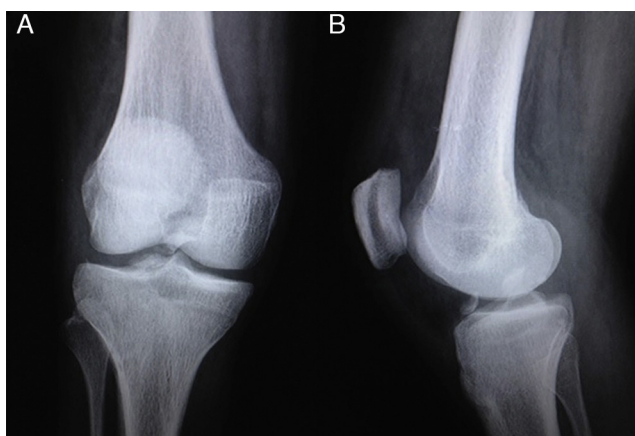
Preoperative radiography of the right knee (A) AP view and (B) profile view.
